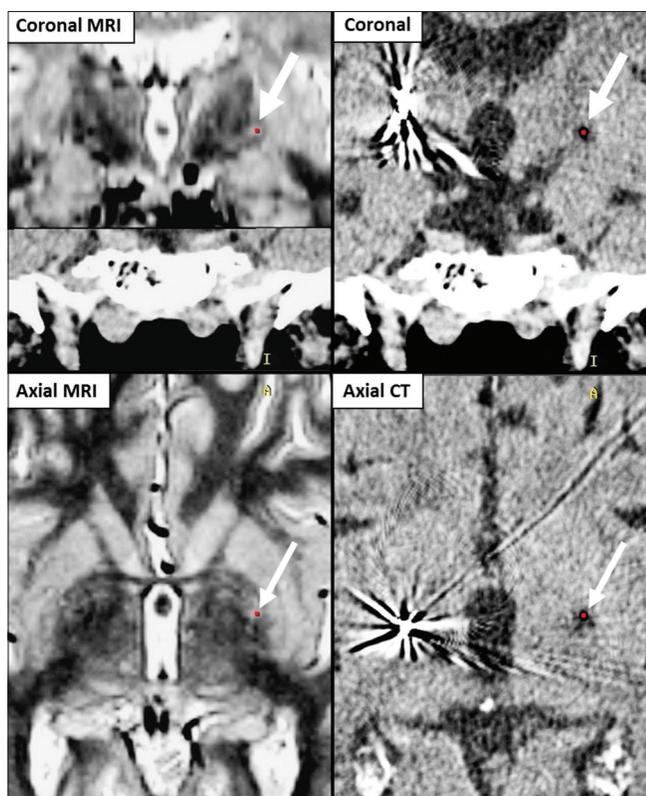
Preoperative magnetic resonance imaging fused with post-lesional computed tomography. The arrows indicate the center of the lesion
